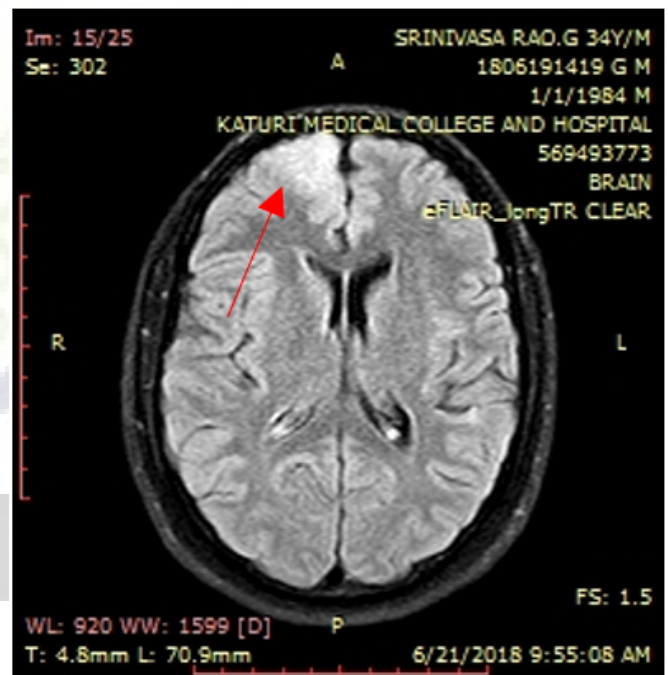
Axial FLAIR image showing focal cortical thickening and hyperintense signal in adjacent white matter in right frontal lobe (arrow).
